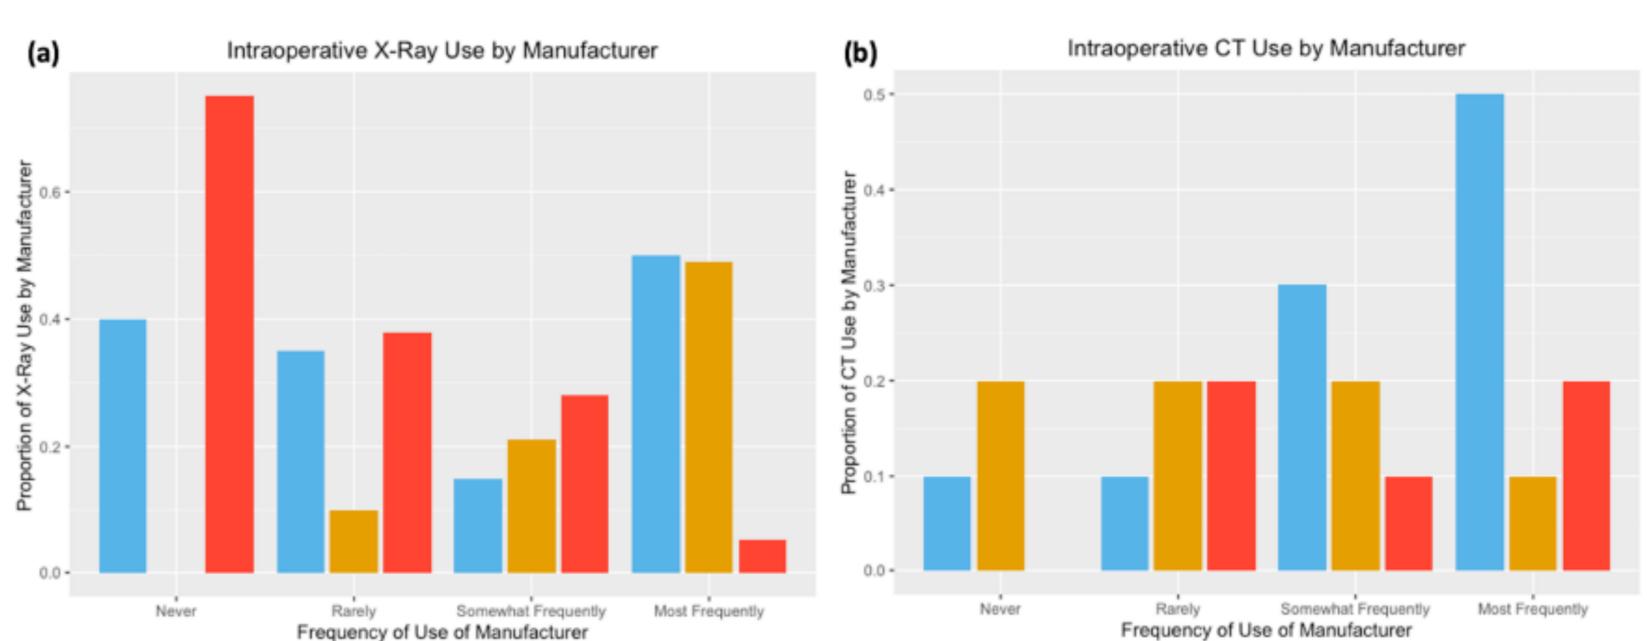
Characterization of Intraoperative Imaging Practices during Cochlear Implantation by Manufacturer & Frequency of Use. Intraoperative (A) X-ray and (B) CT imaging use were characterized accordingly to the cochlear implant manufacturer and the frequency of use by the participating surgeon. Responses were categorized as: never, rarely (1-33%), somewhat frequently (34-66%), and most frequently (67-100%). Key: Blue = Advanced Bionics; Yellow = Cochlear Corporation; Red = MED-EL.
